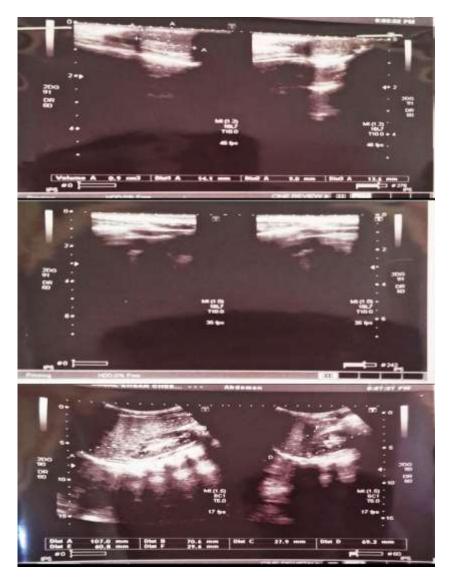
Ultrasound image of the scrotum region in the patient
